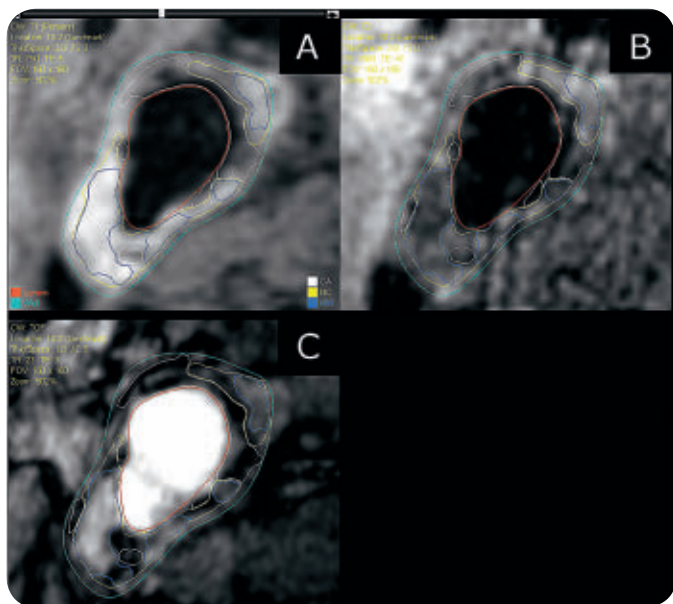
MRI-PlaqueView delineates plaque components such as calcium (white), necrotic core (yellow), and hemorrhage (blue). (A) T1w (B) T2w (C) TOF.
